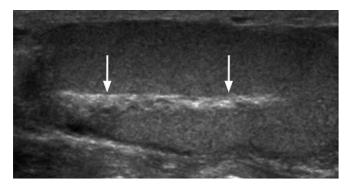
Adapted from Figure 2 of Kühn AL, Scortegagna E, Nowitzki KM, Kim YH. Ultrasonography of the scrotum in adults. *Ultrasonography*. 2016;35(3):180–197. doi:10.14366/usg.15075.
